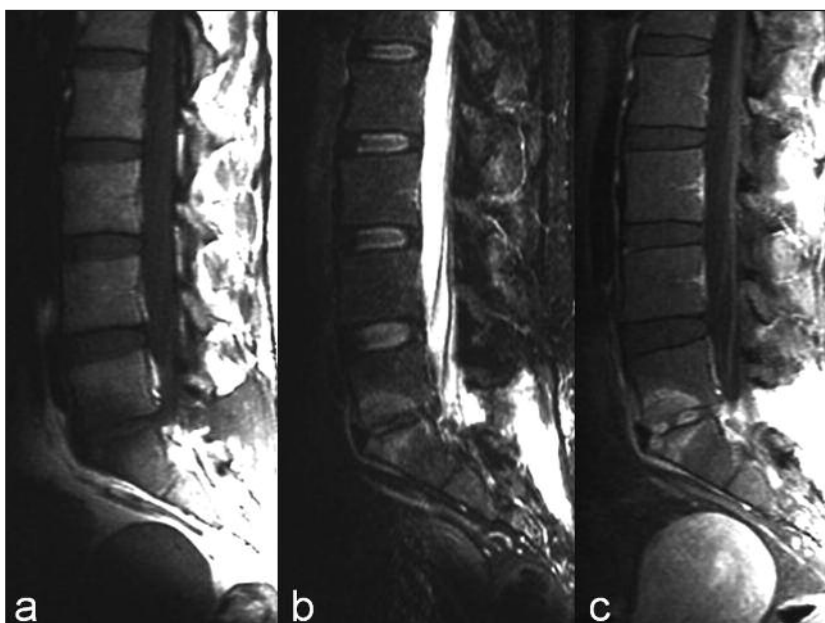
Pyogenic spondylodiscitis at L5-S1 level in a 47-year-old man. (a) Sagittal T1-weighted MR image demonstrating decreased signal within the bodies of L5 and S1 and slight loss of sharpness of the adjacent vertebral end plates. (b) Sagittal fat-suppressed T2-weighted image and (c) sagittal contrast-enhanced fat-suppressed image show hyperintensity and enhancement of L5 and S1 bodies and intervertebral disc respectively.
